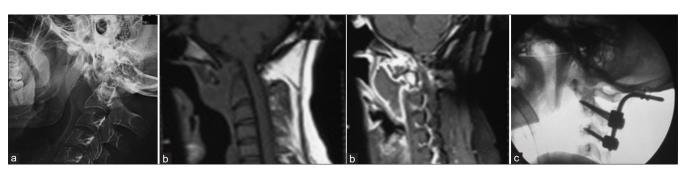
(a) X-ray cervical spine lateral view showing increased atlanto dental interval (13 mm) with radio dense shadow in between. (b) Magnetic resonance imaging cervical spine in sagittal T1-weighted image and contrast showing prevertebral retro-oropharyngeal abscess. (c) Immediate postoperative cervical X-ray days showed beautiful correction.
